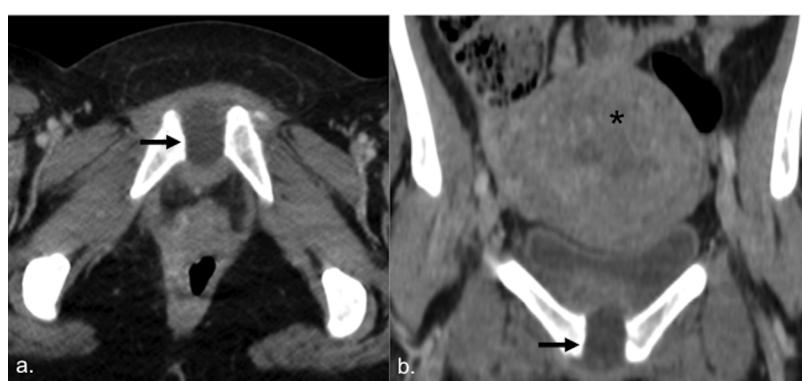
Septic arthritis of the pubic symphysis in a 26-year-old woman on the sixth day after giving birth to twins. Axial (a) and coronal (b) CT images show a hypodense collection with peripheral enhancement (arrows) in the pubic symphysis and an enlarged puerperal uterus (*). Microbiology testing revealed growth of *Escherichia coli*.
